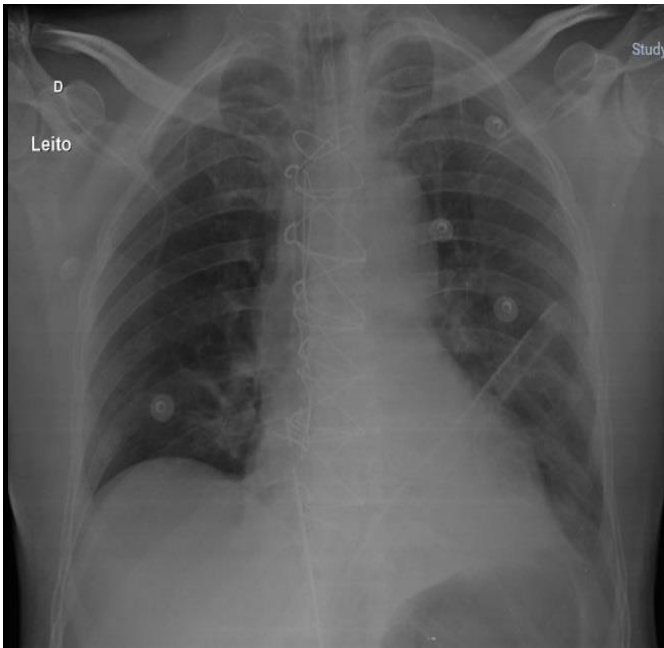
Chest radiography on the 1st postoperative day with normal aspect
